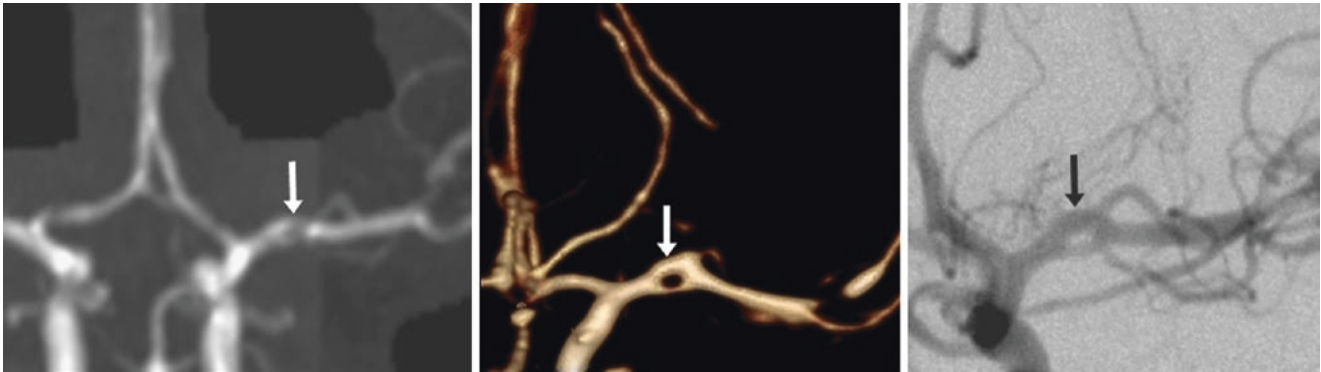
29-year-old with a fenestration of the M1 segment of the left MCA (*arrows*), initially suspected on a 3DTOF MRA AP view (*left*) and later confirmed by similar views from a 3D VR CTA (*middle*) and a catheter DSA (*right*)
